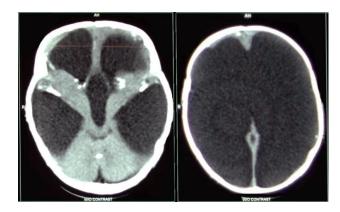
CT scan brain at the age of about 4 months showed marked hydrocephalus and decreased cortical calcifications.
